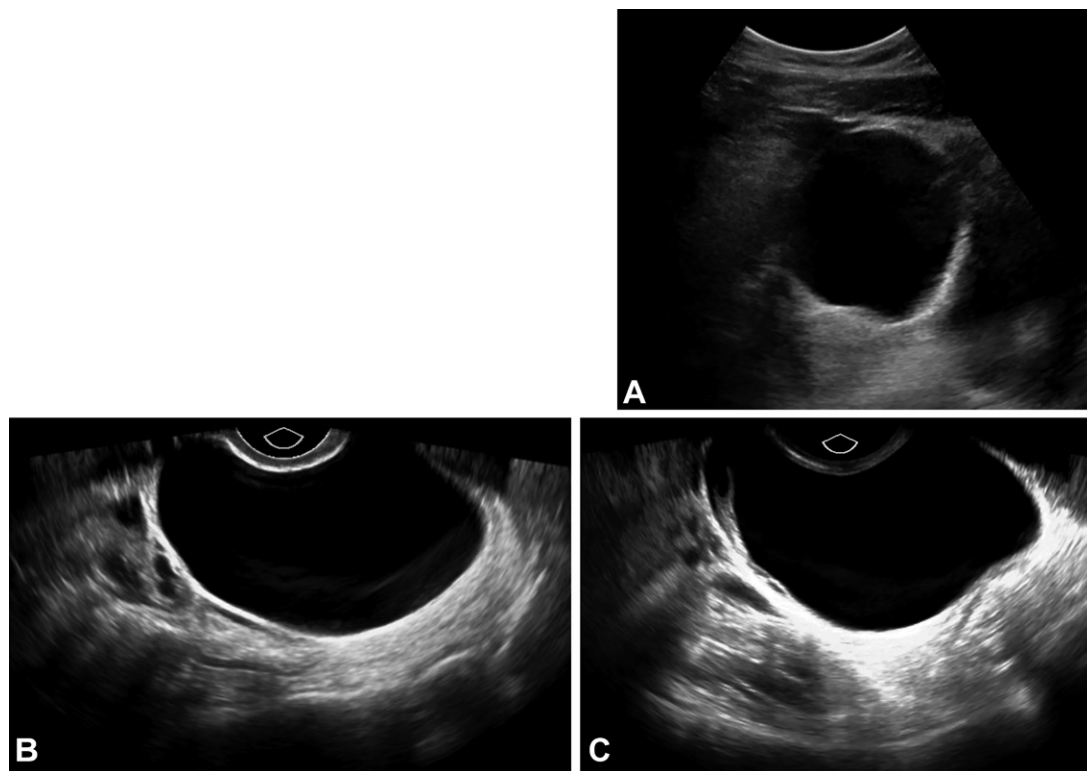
Simple cyst in a premenopausal woman who underwent multiple follow-up examinations. (A) Transabdominal gray-scale US image from initial US performed to characterize an incidental cystic lesion at CT (not shown) shows a 7.7-cm simple anechoic right ovarian cyst. (B) Transvaginal gray-scale US image obtained at 1-year follow-up shows the simple anechoic cyst, which was reported to have increased in size to 8.2 cm. (C) Transvaginal gray-scale US image obtained 2 years after the initial US image shows the same simple cyst, but this time it was reported to have decreased in size to 6.4 cm. Multiple follow-up US examinations were performed over several years because slight changes in size were reported. These variations in size were likely the result of the measurement technique and differences in transducer pressure.
